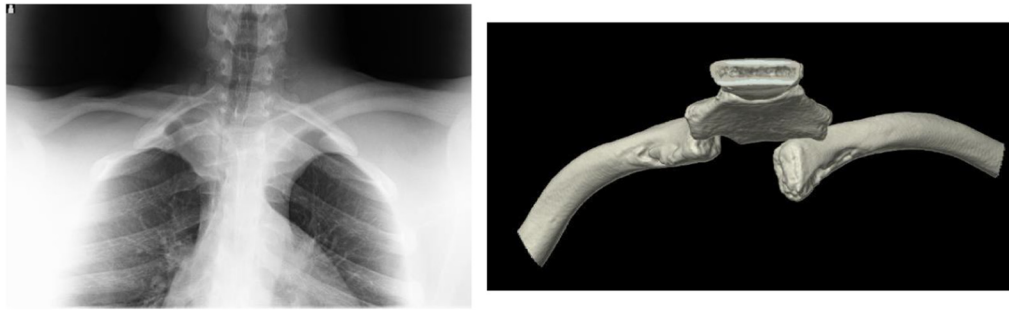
Pre-reduction X-ray and CT scan.
